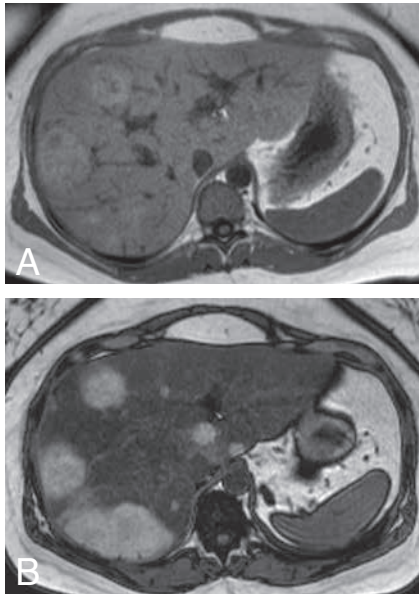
Axial T1 in-phase (A) and out-of-phase (B) MR images show isointense to mildly hyperintense lesions on the in-phase image (A) and clearly hyperintense lesions on the out-of-phase image (B). Notice also the signal drop-off of the liver parenchyma on the out-of-phase image due to steatosis.
